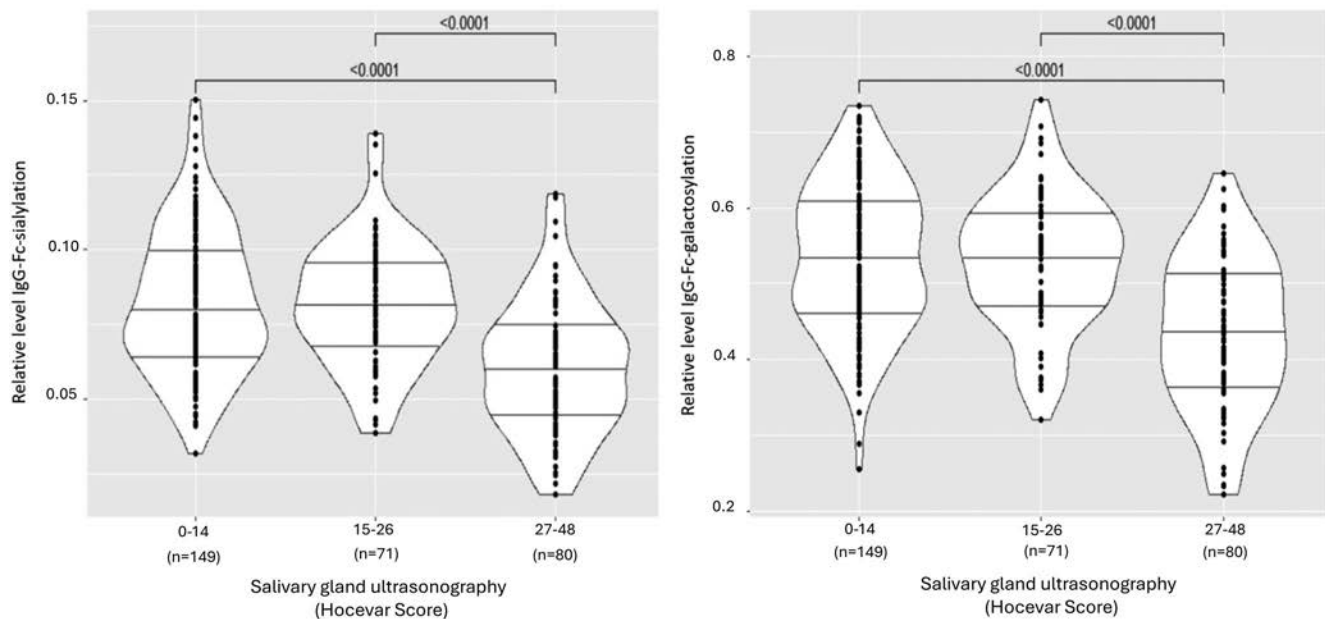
Relative levels of IgG Fc sialylation and galactosylation in function of salivary gland involvement assessed by ultrasonography.
